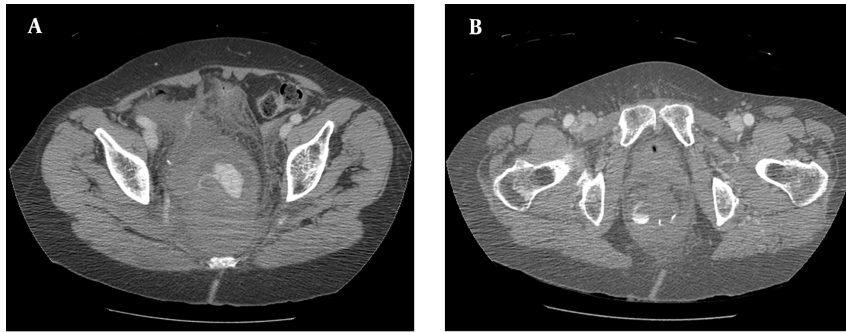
A, Post-operative CT scan: Giant peri-rectal and retroperitoneal pelvic hematoma; B, Post-operative CT scan: Signs of active bleeding
